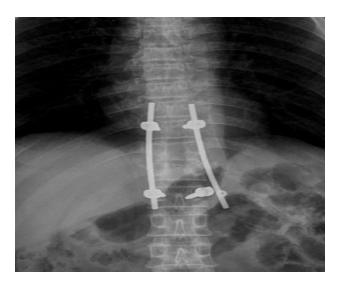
X-ray DL Spine AP view showing the dislodged inner tightening screw and laterally displaced rod on the left side.
